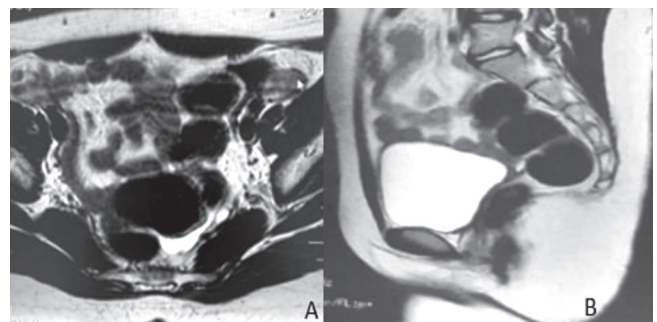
(a). MRI, showing the testis, T2 sagittal plane section-The uterus and vagina are not visible between the bladder and rectum. (b). T2 Axial section- The testicles are at the iliac fossa (small arrow showing the left testis).
